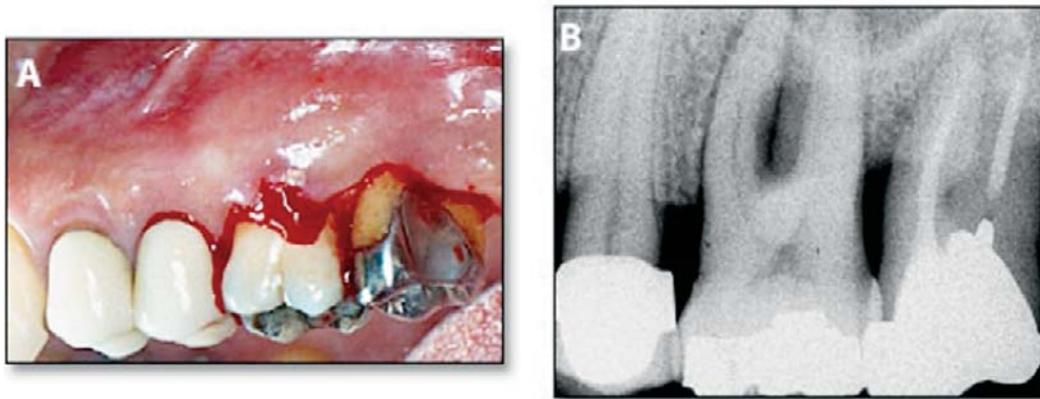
(A) Clinical and (B) radiographic characteristics in a patient with a periodontal abscess during SPT.
